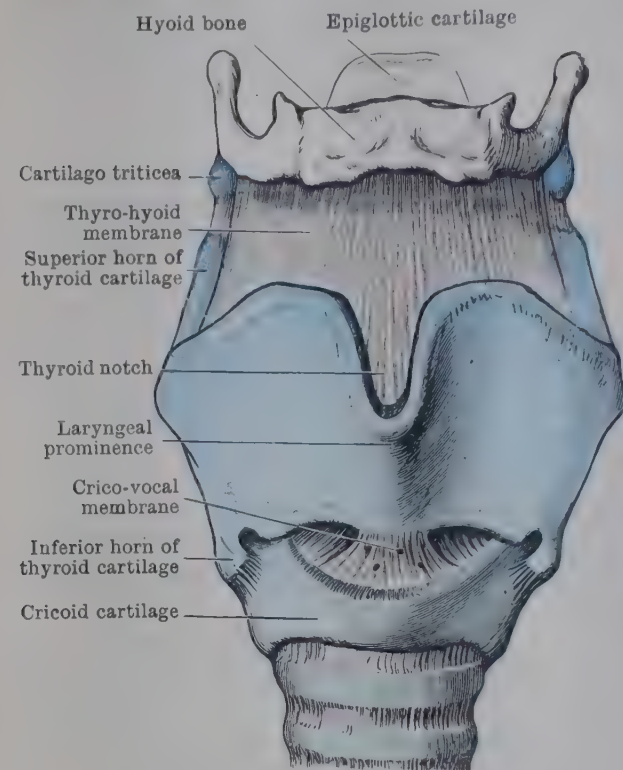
ANTERIOR ASPECT OF CARTILAGES AND LIGAMENTS OF LARYNX.
